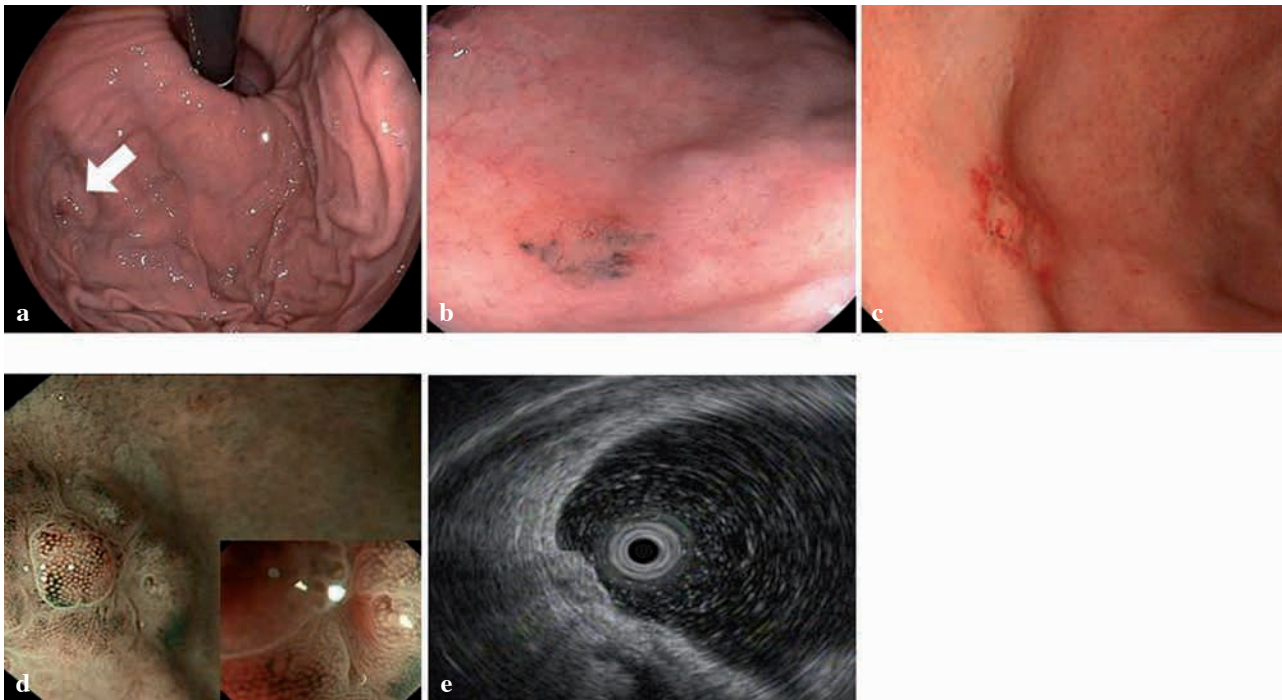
(a) Endoscopic examination (first esophagogastroduodenoscopy) revealed black pigmentation (white arrow) on the posterior wall of the greater curvature of the gastric fornix. (b) The close view presented a flat lesion with black pigment dispersion. (c) Black pigmentation was scarcely observed in the tumor at 7 weeks post initial discovery. (d) Magnifying endoscopy with narrow band imaging showed a slightly irregular micro-surface pattern and regular micro-vascular pattern around the scar after biopsy (moderate and full zoom). (e) Endoscopic ultrasonography portrayed the discontinuity in the third layer.
